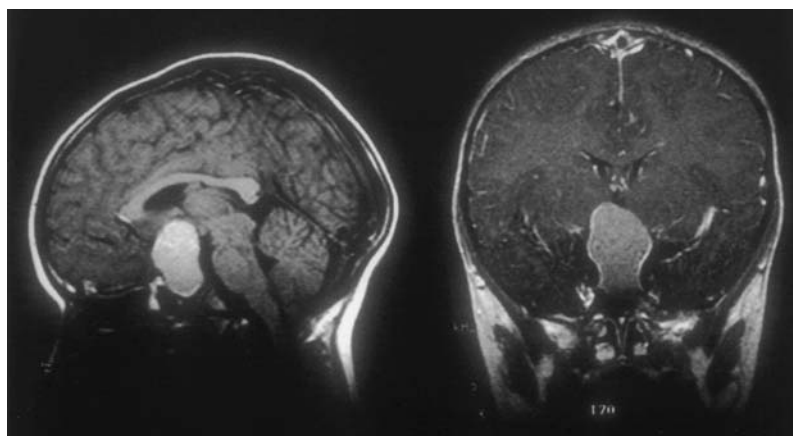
Sagittal (left) and coronal (right) gadolinium-enhanced MRI (T1), showing a craniopharyngioma. This example is entirely cystic in appearance, with pronounced enhancement of the wall.
